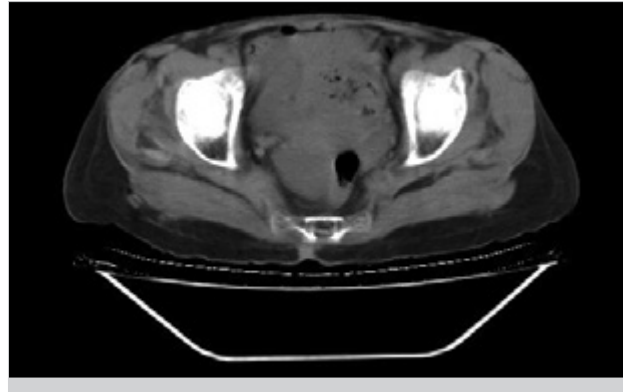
Minimal free fluid in the pelvic sections of abdominal computed tomography
